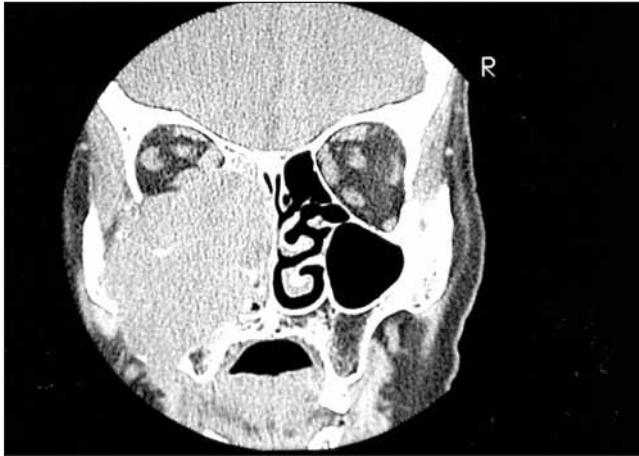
Coronal CT revealed a solid mass invading the orbital soft tissue, intranasal cavity, cheek and palatal region.
